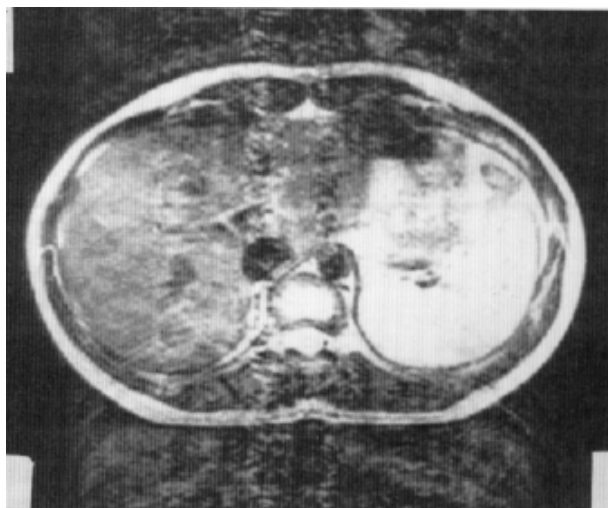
Conventionally acquired MRI scan of the abdomen. Because scan times are relatively long compared to normal physiological motion such as breathing, image artifacts tend to accumulate during the scan. Due to the Fourier-encoding process used in the collection of conventional MR data, however, the resulting artifacts are not simply a blurring of the image. Instead, as shown here, even simple motion of the chest wall results in gross contamination of the image, with artifacts extending well away from the moving tissue. Note also that the image contrast may be obscured (as in the anterior portion of the liver) because of the signal displacement. TR: 2000 msec, TE: 20 msec, slice thickness: 10 mm
